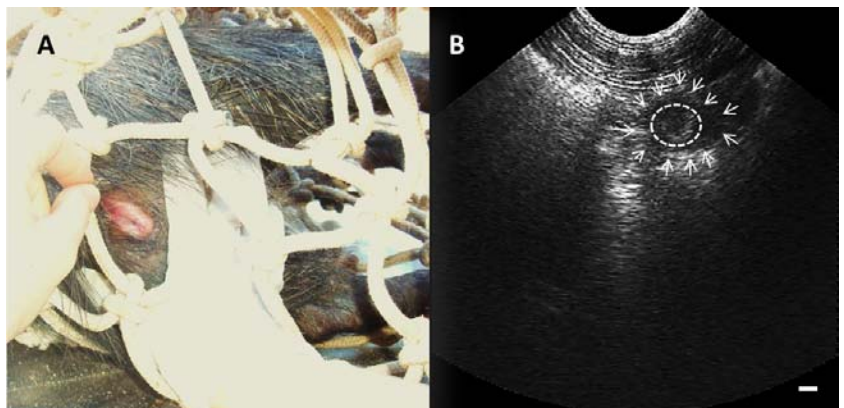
Estrous signs in collared peccary (*Pecari tajacu*). (A) vulvar opening and hyperemic vaginal mucosa; (B) sonogram of an ovary (white arrows) presenting the pre-ovulatory follicle (ellipsoid).
